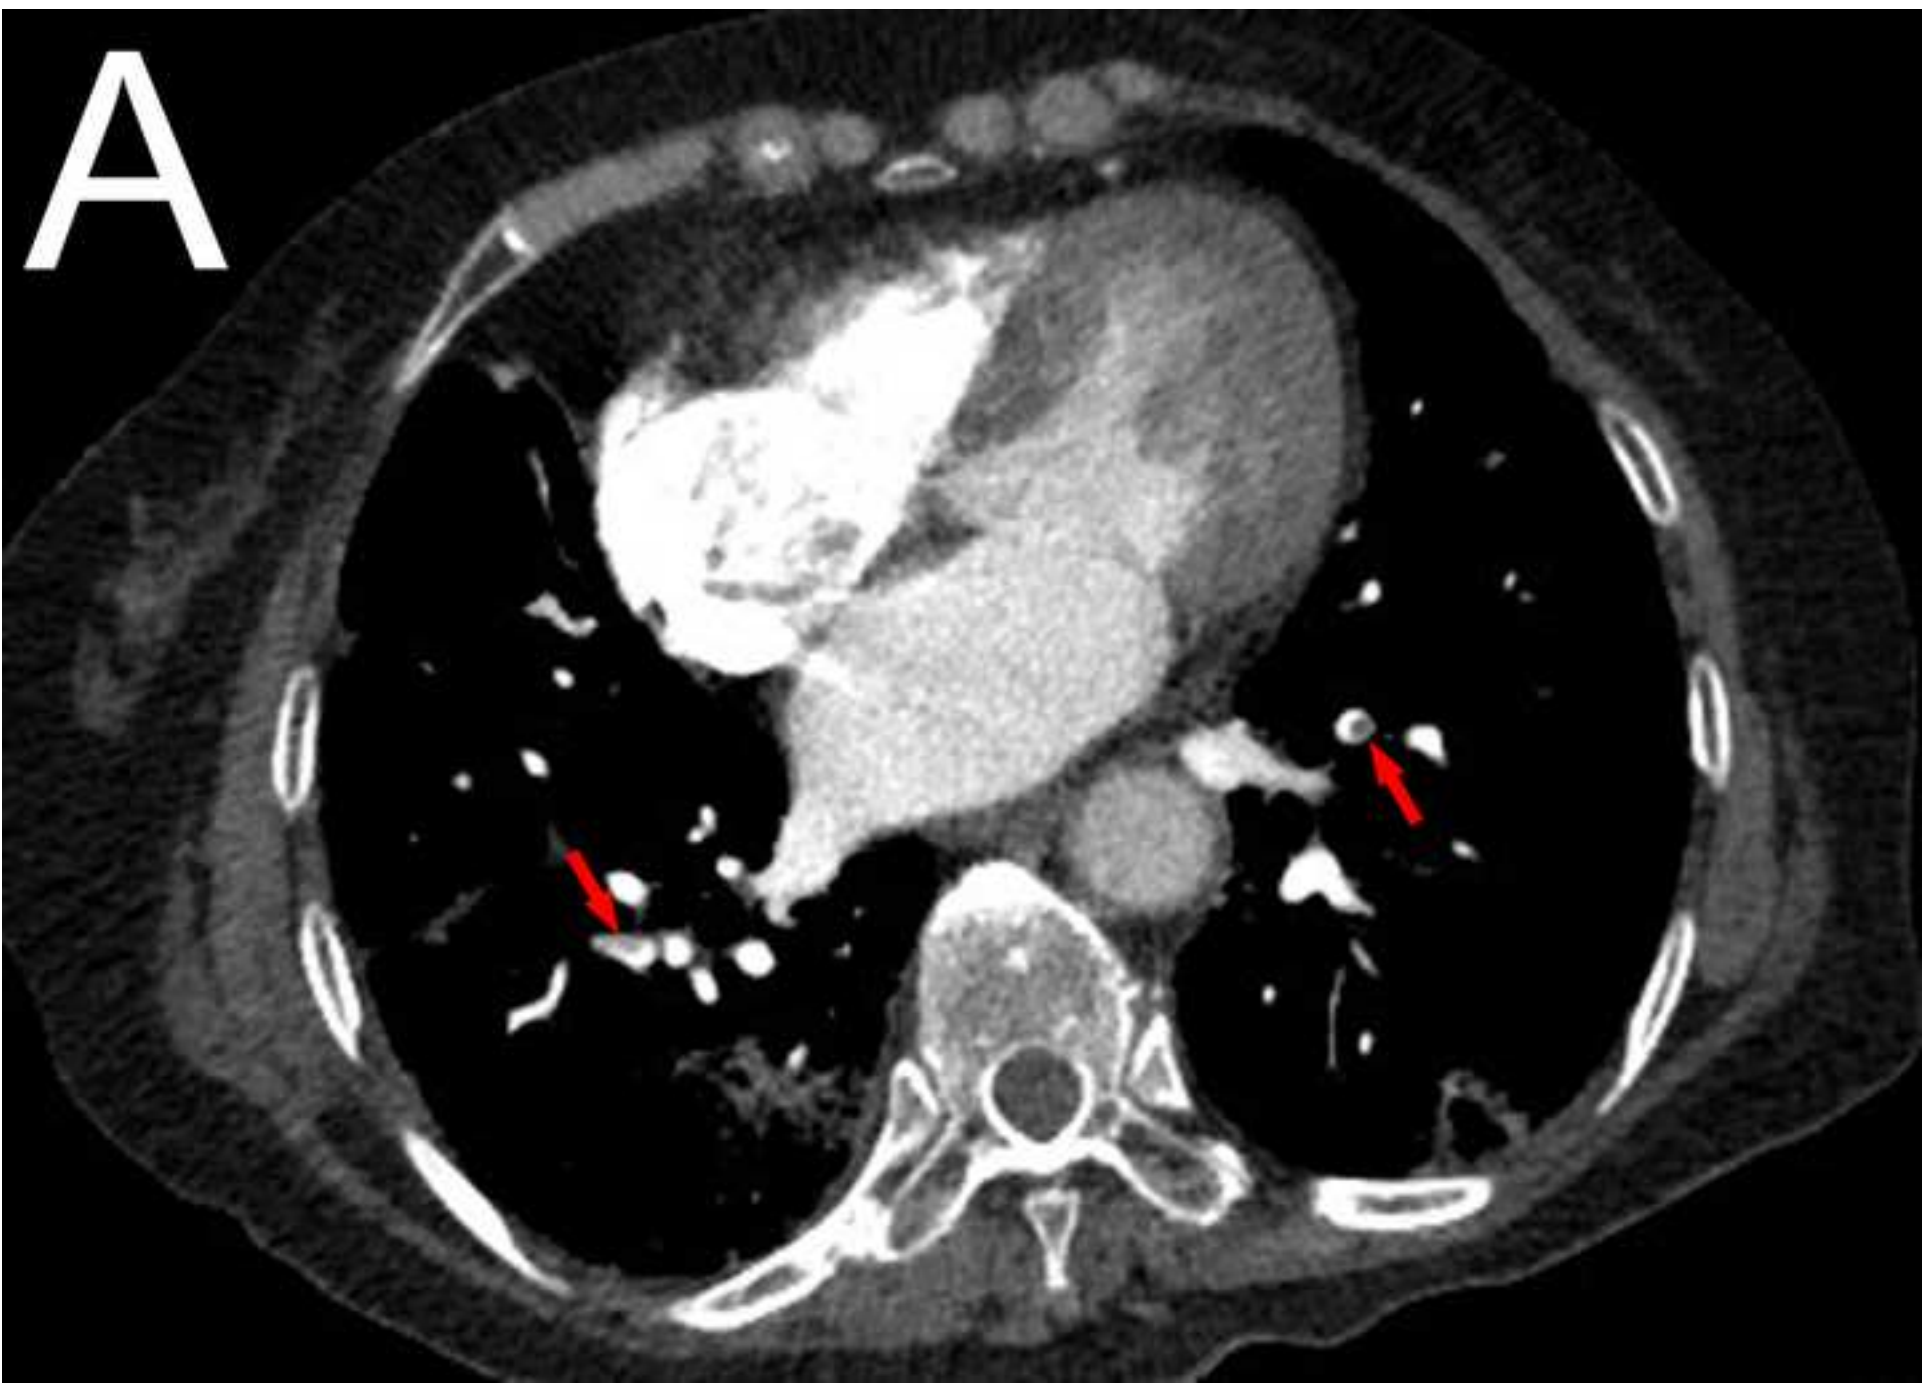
CTPA findings in a 76-year-old female patient with severe COVID-2019 pneumonia. (A): thrombus (arrow) occurred in bilateral lower lobe pulmonary artery on axial CTPA image. (B): axial CT image showed that density of both lungs increased widely, showing a "white lung" appearance, indicating the patient was at peak stage.
